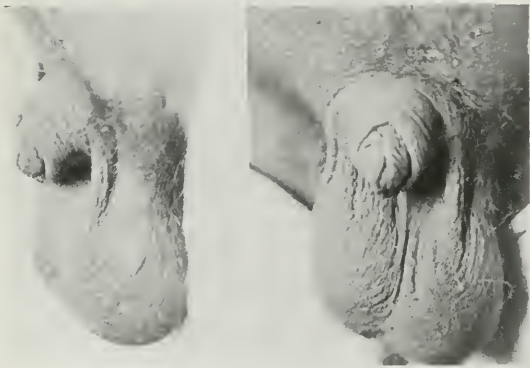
EPITHELIOMA OF THE PENIS. SHOWING THE RESULTS OF COMBINING ELECTRO-COAGULATION AND ROENTGEN RAY TREATMENT.
